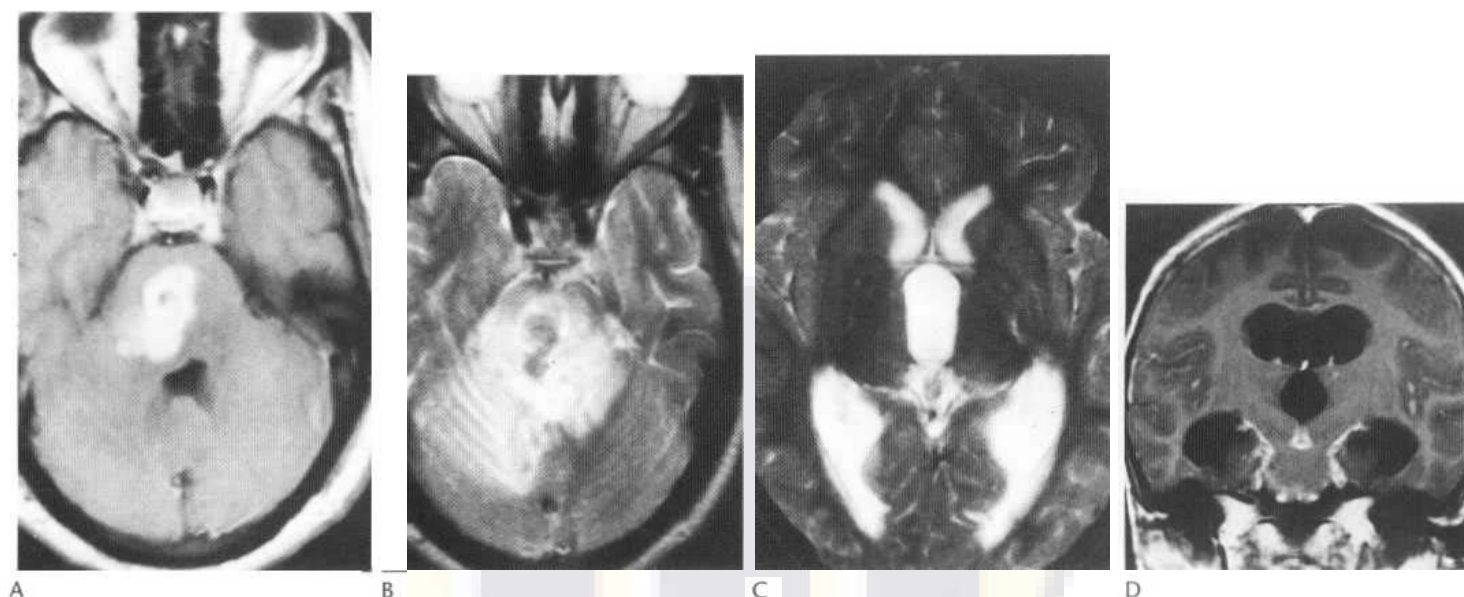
An irregular enhancing tuberculoma is shown within the pons on the postcontrast axial T_1 -weighted MR image. (A) The lesion is of relatively low signal on the T_1 axial image (B) and there is extensive vasogenic oedema and some modest mass effect with distortion of the 4th ventricle. Axial T_2 -weighted MR (C) demonstrating third and lateral ventricular hydrocephalus with transependymal oedema around the occipital horns. This was secondary to tuberculous meningitis. On the coronal T_1 postcontrast image (D) there is nodular meningeal thickening and enhancement around the brainstem and cerebellum.
